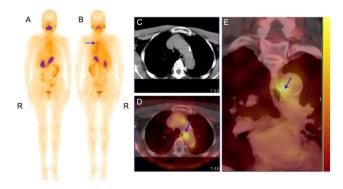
A representative case of abnormal radioactive uptake lesions in the mediastinum (A, B: 99mTc WBS; C, D and E: 99mTc SPET/CT) which show activity in esophagus (blue arrows) representing physiological uptake.
